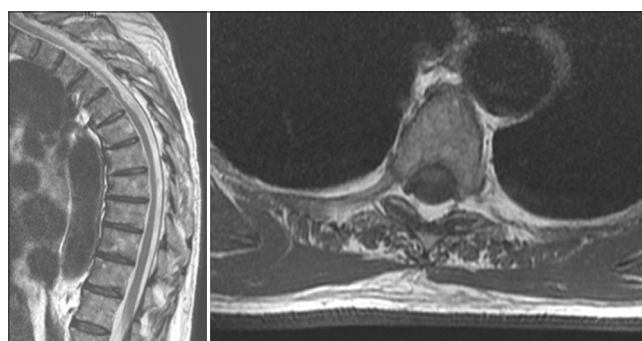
MRI T2-weighted sagittal and axial images. Anterior kinking and flattening of the spinal cord at T5, widening of the subarachnoid space posterior to the cord
